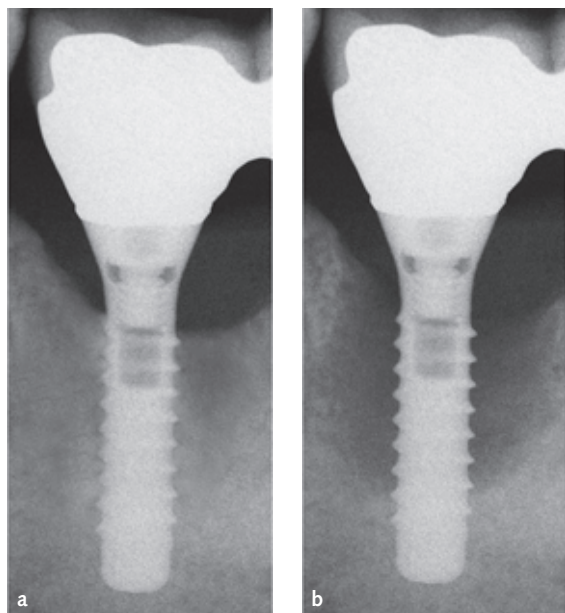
Baseline radiograph of a longer implant (12 mm) with no sign of bone loss (a) paired with a follow-up visit at 5 years with 5 mm of bone loss (b).
